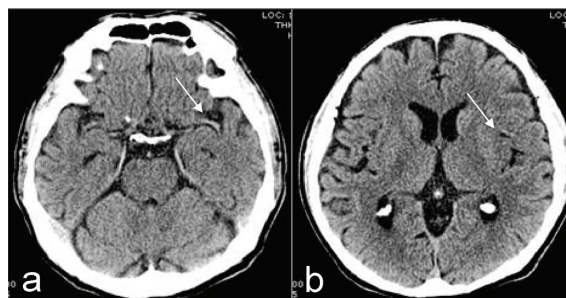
A 73-year-old man with acute infarction. a, b) non-enhanced CT (NCCT) scan revealed acute thrombus in the horizontal left middle cerebral artery (arrow in a) and loss of gray-white differentiation at the left insular cortex (arrow in b).
